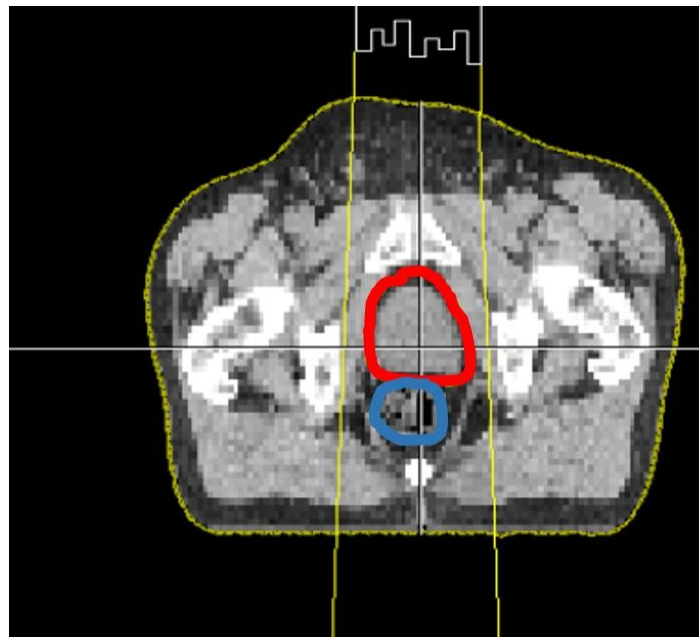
IMRT plan for the prostate as seen on an axial CT scan.
